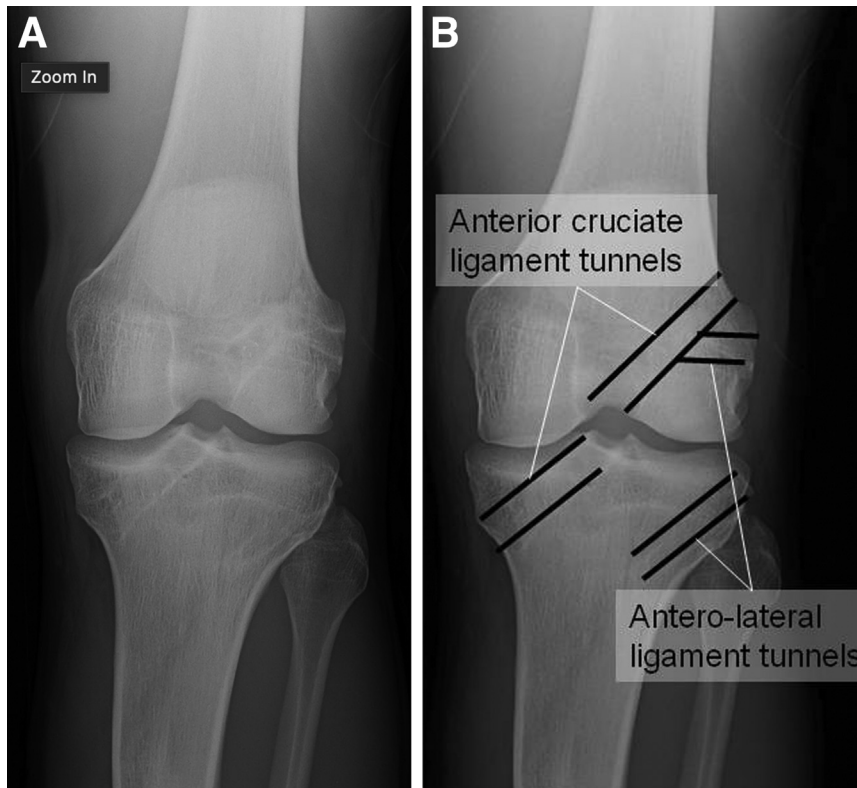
A 25-year-old male patient underwent a combined reconstruction of the anterior cruciate ligament and the anterolateral ligament and presented graft failure with a recurrence of instability. (A) Preoperative radiograph. (B) Preoperative radiograph with the previous reconstruction tunnels highlighted
